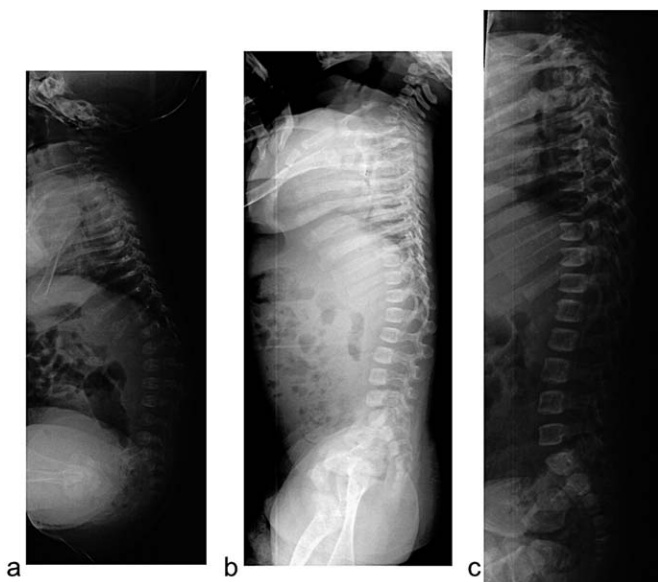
Lateral X-ray films of column in infant treated with neridronate from age 1 month; (a) at beginning, (b) after 6 months, and (c) after 12 months of treatment. It is evident progressive improvement of vertebral bodies.
